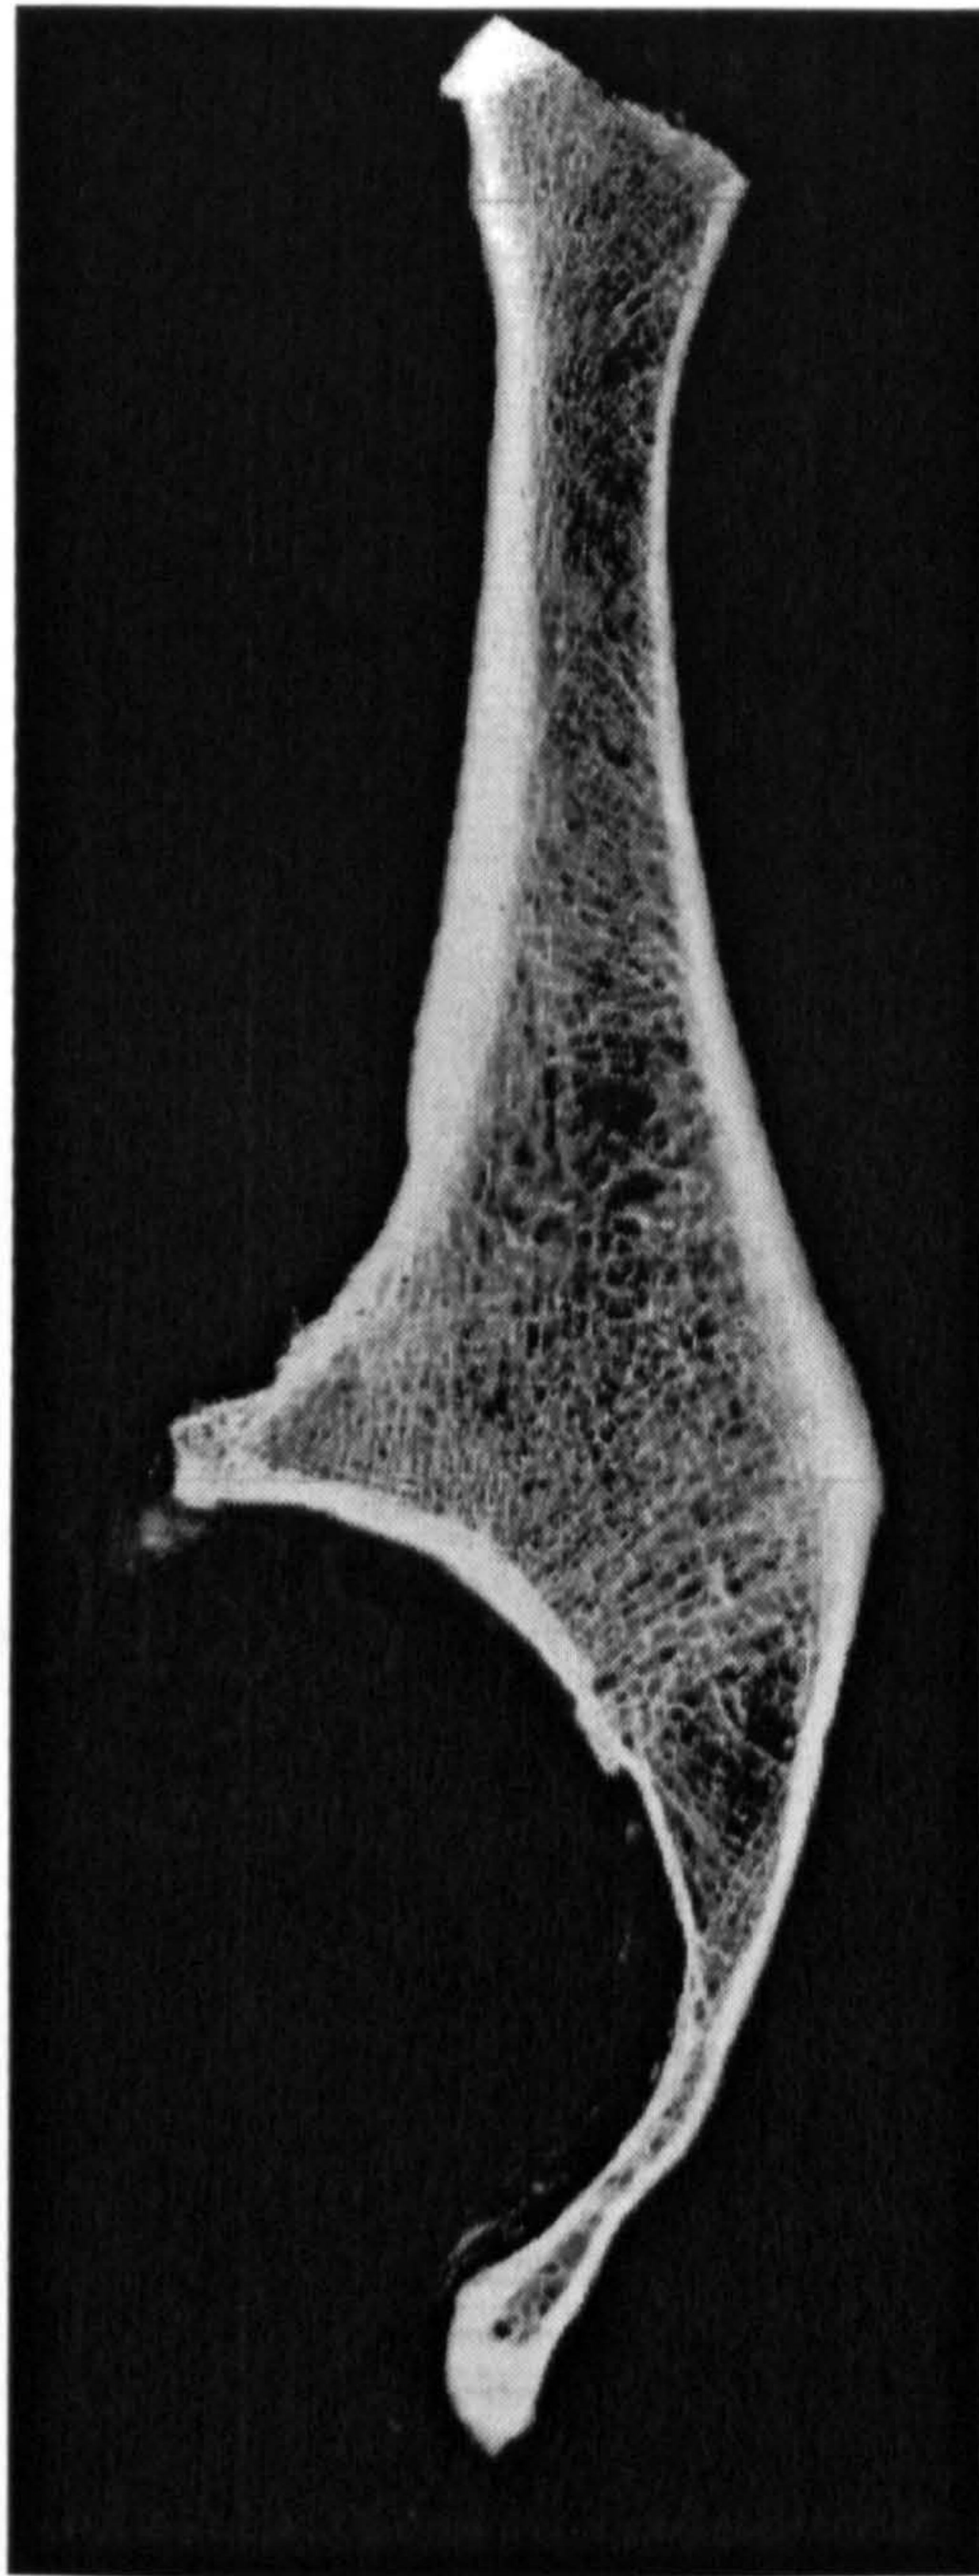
Contact radiograph of a vertical slice through the acetabulum and the ilium, showing the weight-bearing dome, the subchondral plate and the medial wall extending down to the acetabular notch.
